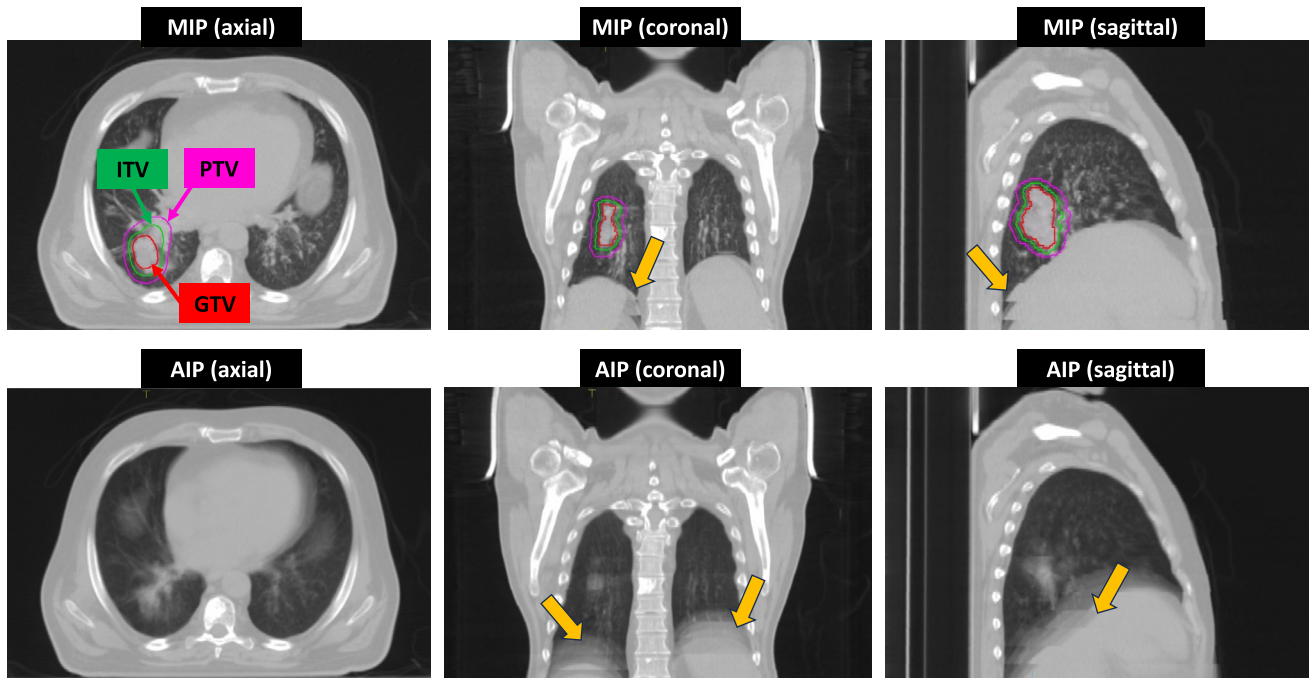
Sample 4DCT images contrasting the difference between maximum intensity projection (MIP) and average intensity projection (AIP) images for a lung cancer case. In these images, the same x, y, z CT slice coordinate is shown and on different views: axial, coronal and sagittal. Both reconstructed images show visible artefacts (indicated with the yellow arrows). In this example, the MIP was used for radiotherapy target delineation where the gross volume tumour
